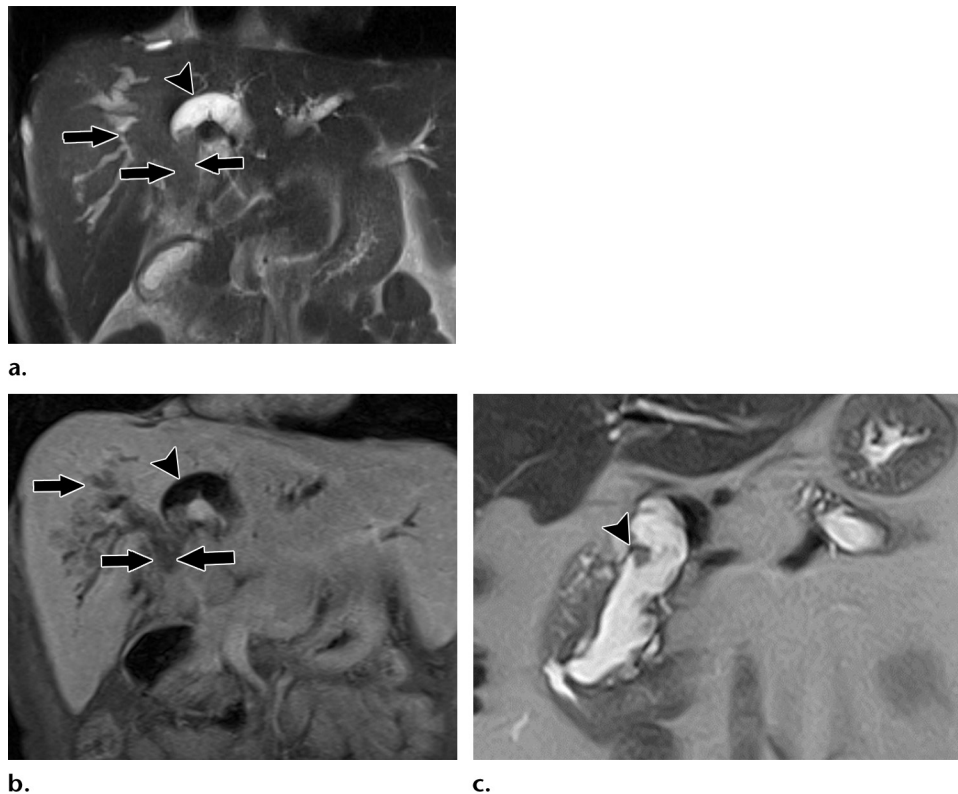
Imaging similarities between the duct-ectatic type of intraductal papillary neoplasm of the biliary tract (a, b) and the main duct type of intraductal papillary mucinous neoplasm of the pancreas (c). (a, b) Coronal T2-weighted (a) and gadolinium-enhanced T1-weighted (b) MR images of a 56-year-old woman show an isointense minimally enhancing intraluminal mass within the common bile duct extending into the right and left intrahepatic bile ducts (arrows) with associated biliary ductal dilatation (arrowhead), findings consistent with the duct-ectatic type of intraductal papillary neoplasm of the biliary tract. (c) Coronal T2-weighted MR image of an 87-year-old man shows a dilated main pancreatic duct with multiple papillary projections (arrowhead) along the wall, findings consistent with the main duct type of intraductal papillary mucinous neoplasm of the pancreas.
